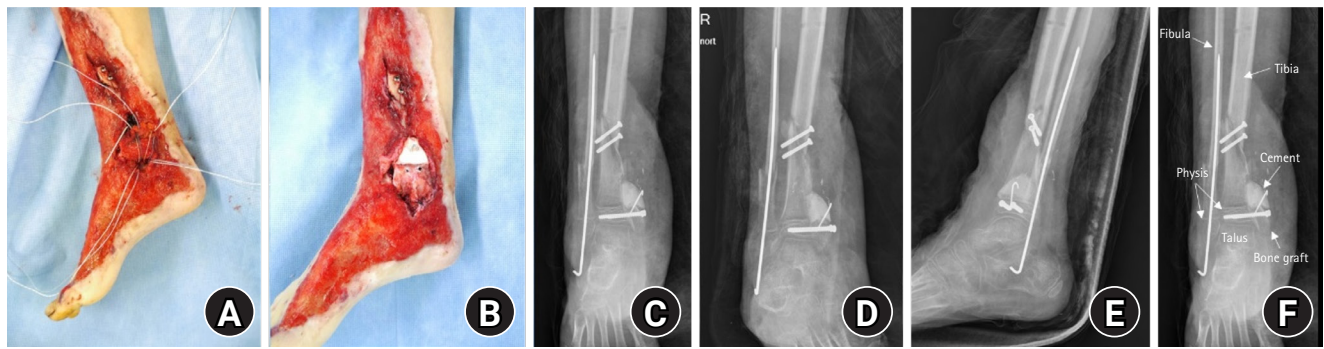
Postmedial malleolus reconstruction. (A) Medial clinical photograph obtained after reconstruction of the medial malleolus using an autologous iliac crest bone graft with internal fixation. (B) Medial clinical photograph obtained after reconstruction, showing restoration of the medial malleolar contour and soft-tissue coverage. (C) Anteroposterior postoperative radiograph demonstrating reconstruction of the medial malleolus with internal fixation. (D) Mortise postoperative radiograph demonstrating reconstruction of the medial malleolus with internal fixation. (E) Lateral postoperative radiograph demonstrating reconstruction of the medial malleolus with internal fixation. (F) Anteroposterior radiograph, showing the reconstructed medial malleolus and surrounding anatomical structures.
